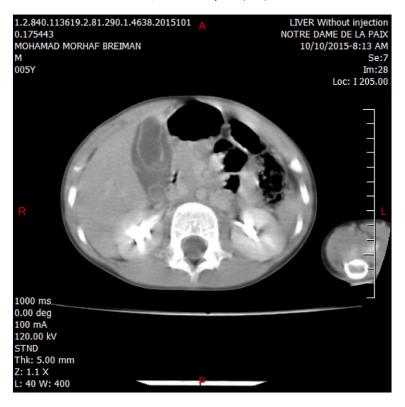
Computed tomography without injection showing the presence of gallbladder distention and intra parietal fluid of low density.
